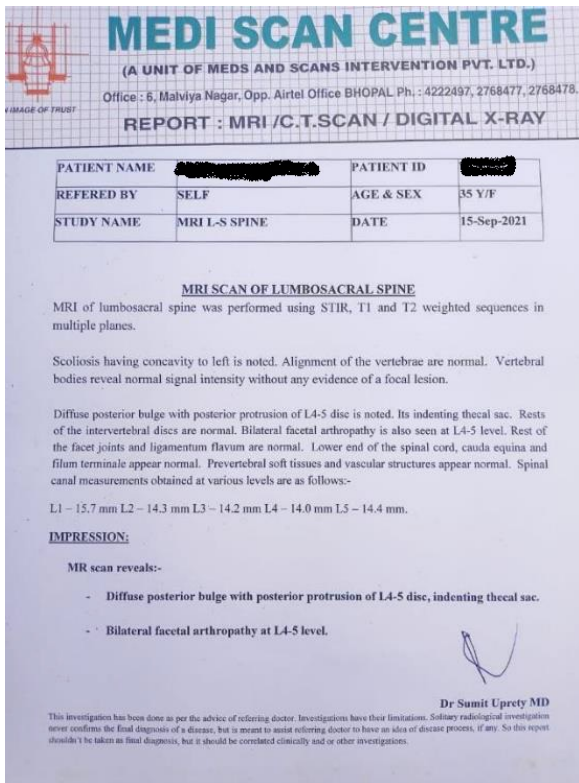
(a). MRI L-S SPINE report of a patient
